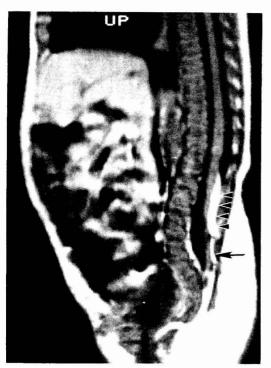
Case 5. T1-weighted MRI scan, sagittal view. Note the low-lying conus stuck to dorsal lipoma (*arrowheads*). The bright signal caudal to this (*arrow*) proved to be a fatty filum.
